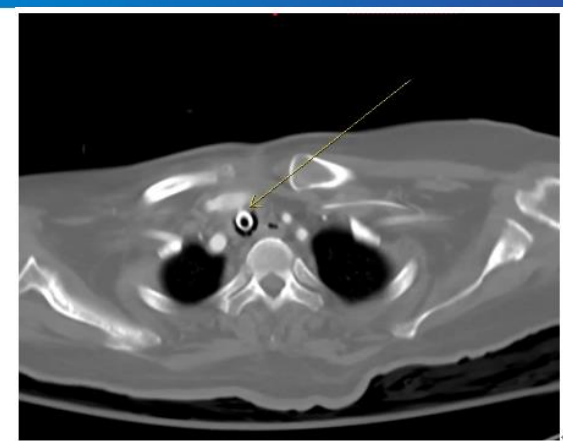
Preoperative Thoracic Aorta CT showed Tracheo-Innominate fistula
